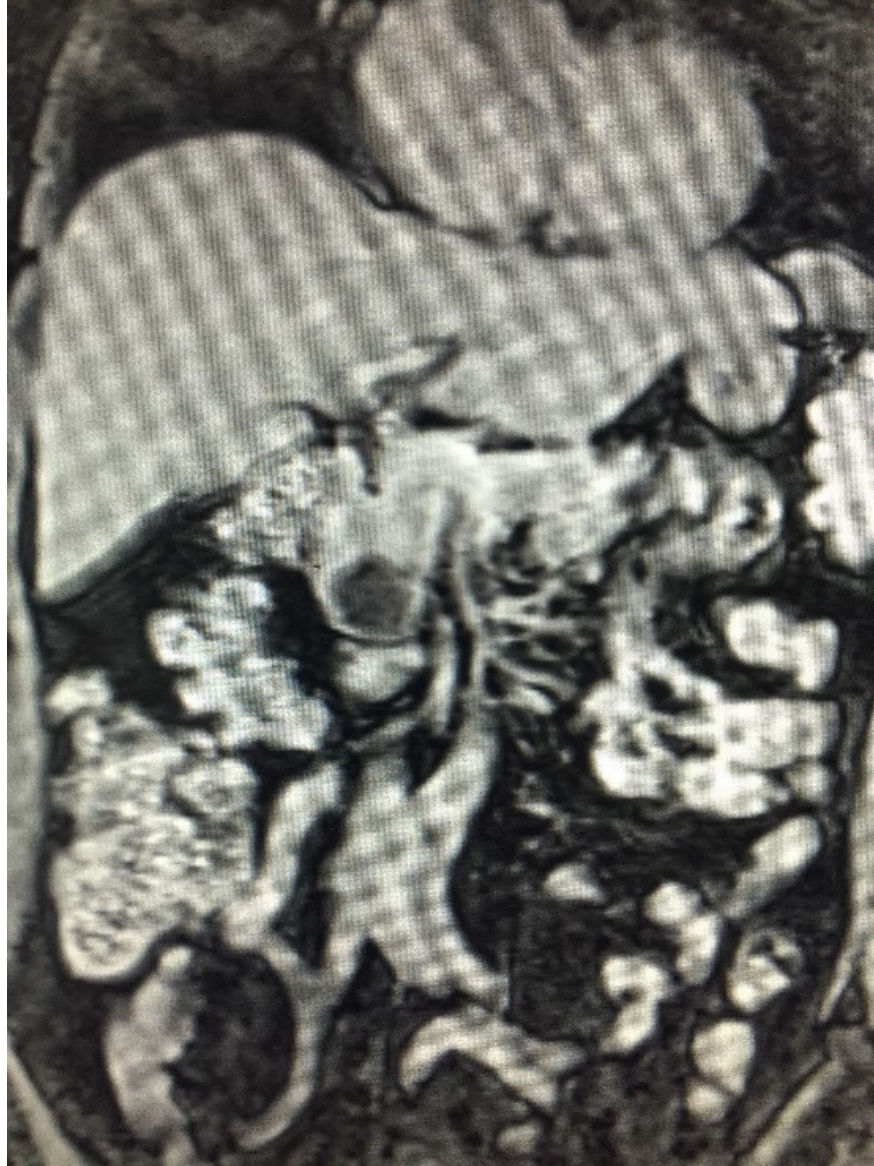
Abdominal MRI showing a 2.5cm well-circumscribed ovalated cystic mass with some septa was discovered in the uncinate process of the pancreas.
